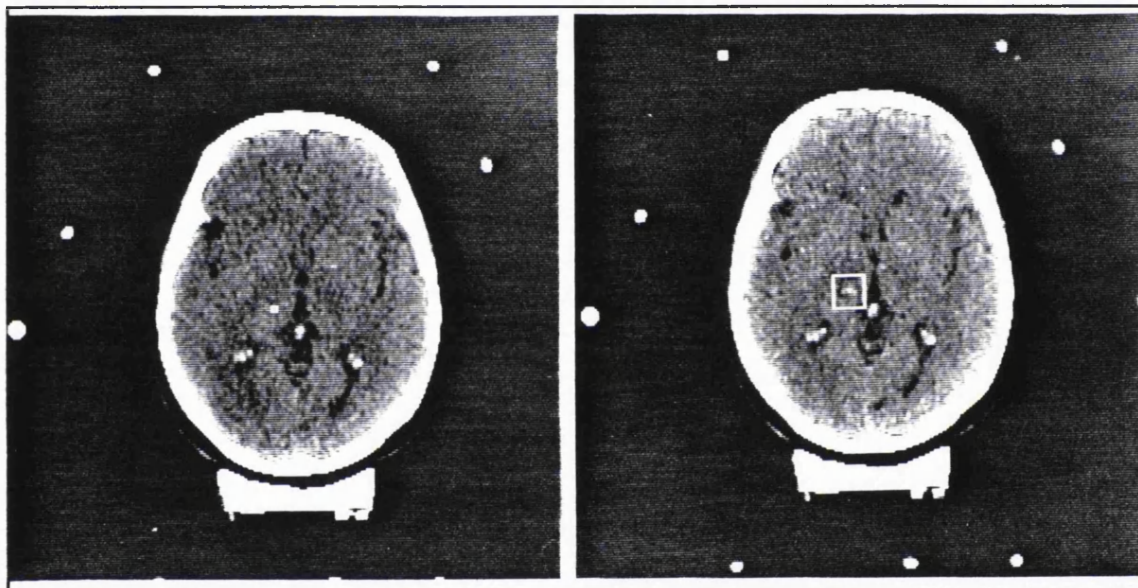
Planning CT indicating thalamic target in VIM.
